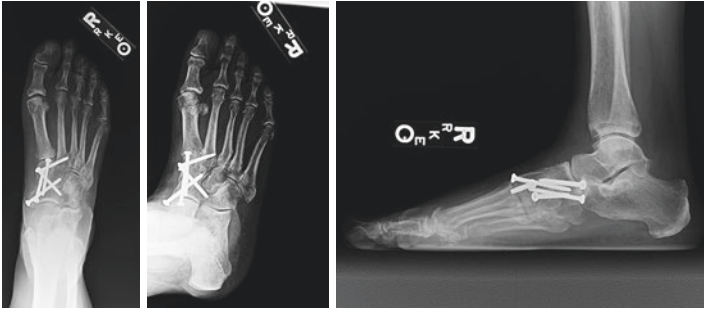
AP, oblique, and lateral radiographs 6 months post-op
